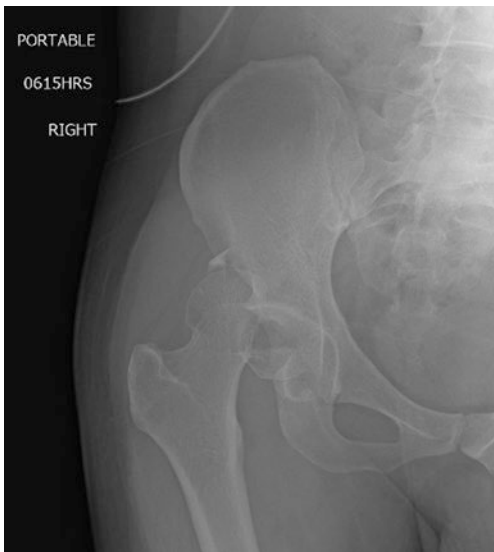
Plain radiographs demonstrating the femoral head fracture-dislocation with an associated posterior wall acetabular fracture (Pipkin IV—not visualized well here). Attention should be paid to the incarcerated femoral head fracture fragment that may block successful closed reduction (Preoperative radiograph. Hamilton General Hospital, Hamilton, Ontario. Taken with patient permission, January 2017)
